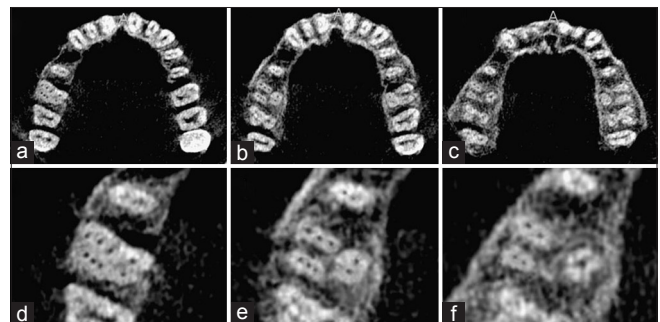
(a-c) Cone-beam computed tomography (CBCT) images of the maxillary arch showing axial sections at the (a) cervical, (b) middle, and (c) apical level. (d-f) Enlarged axial section CBCT images of tooth #14 at the (d) cervical, (e) middle, and (f) apical level showing three roots and eight root canals
